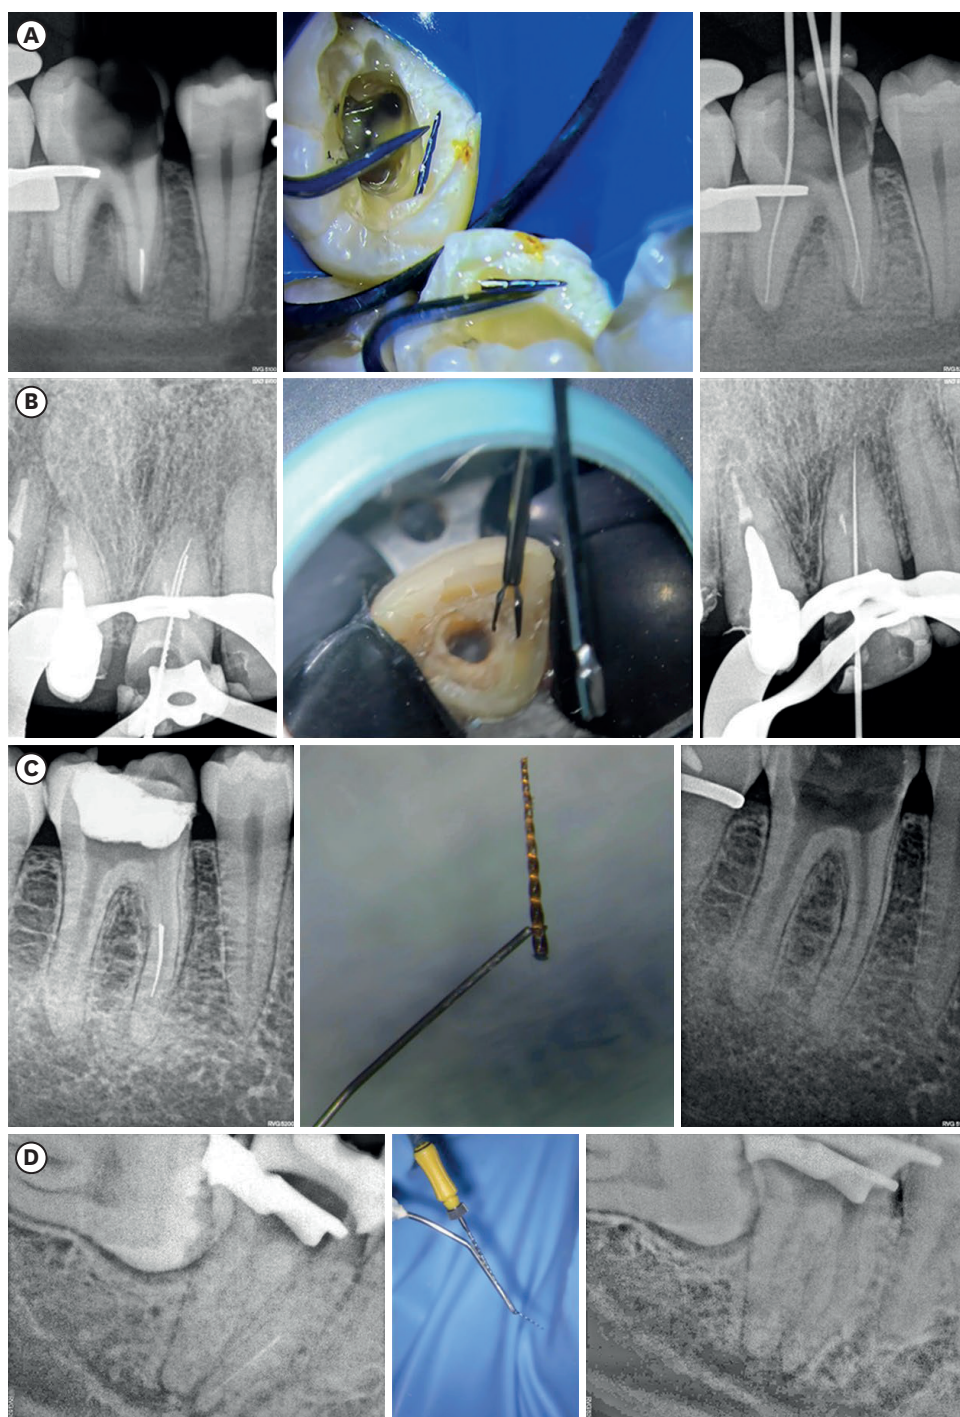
Removal system of fragments. (A) Ultrasonic tips; (B) micro-tweezer; (C) loop; (D) tube system.
